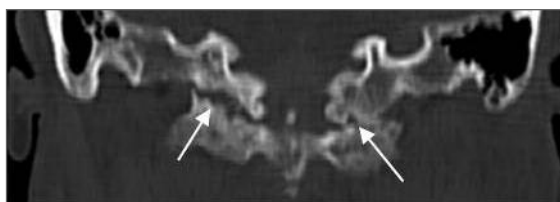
Coronal CT reconstruction showing erosive destruction of atlanto-occipital joints (white arrows)
